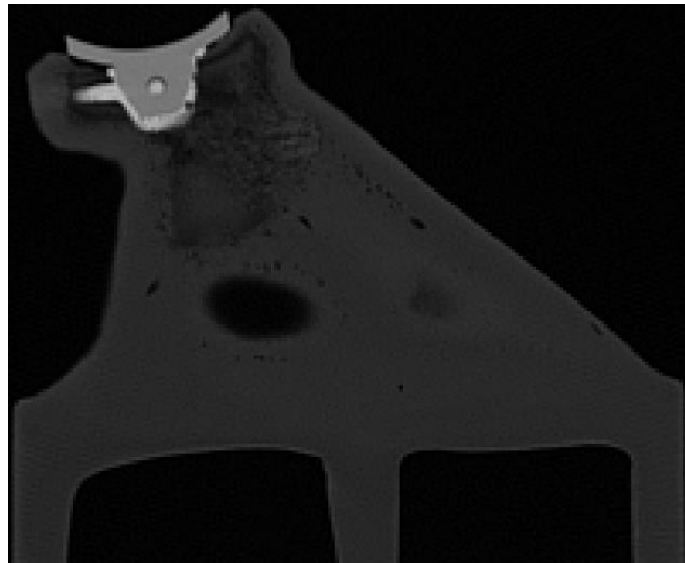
CT scan for robot prepared cemented standard keel implant.
